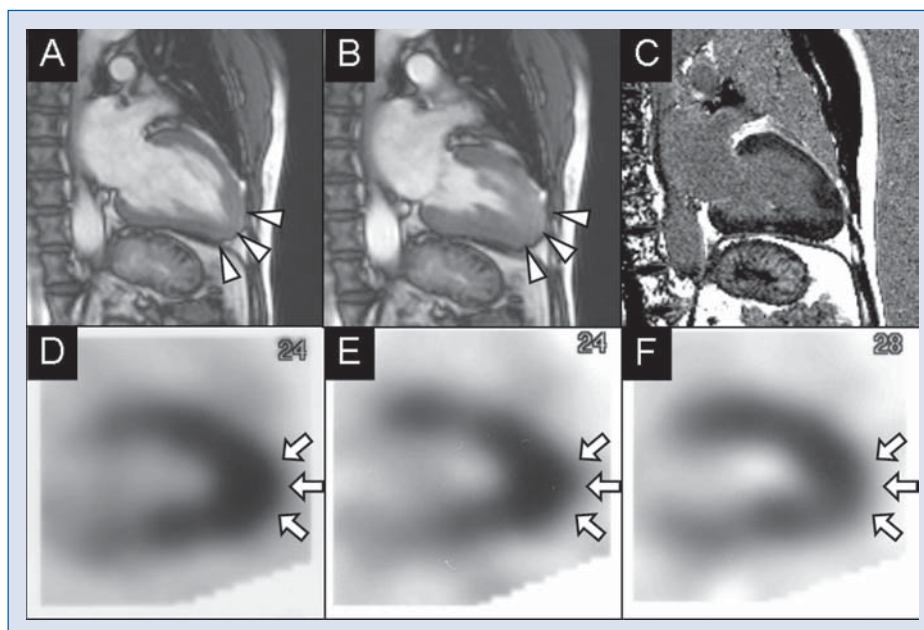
Cardiac magnetic resonance imaging cine imaging at diastole (A) and at systole (B) confirms left ventricular apical myocardial hypertrophy with normal wall motion (arrowheads). Gadolinium late enhancement imaging (C) shows no hyperintense areas. ²⁰¹Tl-TICl images at early (D) and late (E) phases and ¹²³I-BMIPP image (F) show significantly increased uptake in left ventricular apical myocardium (arrows).
